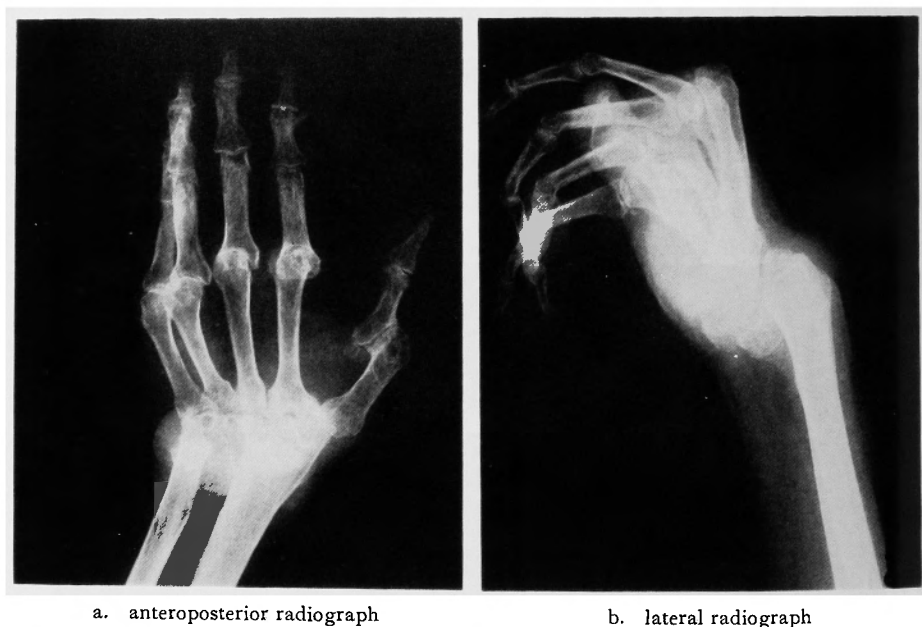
Preoperative radiographs of the left hand showing anterior dislocation of the radiocarpal joint.
